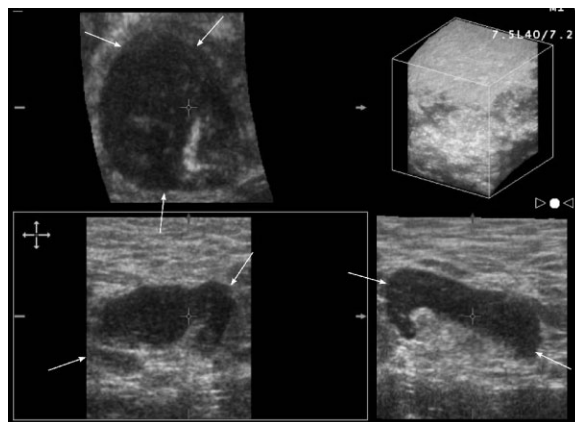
An ultrasound three-dimensional image of an axillary lymph node (arrows) with ultrasound features of a malignant lymph node: lobulated in shape with thickened cortex and irregular, star-shaped hilum, in a 58-year-old male with a small lymphocytic lymphoma.
